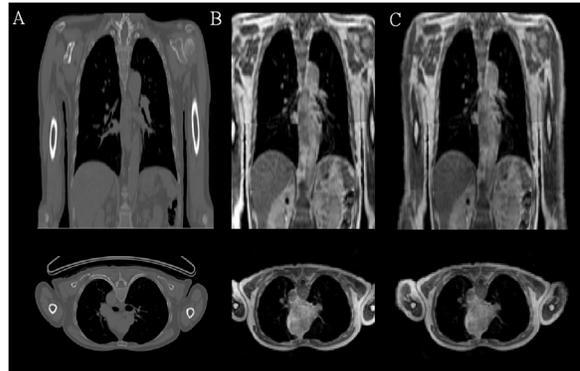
A) Reference CT. B) Truncated MRI. C) MRI compensated for truncation.
